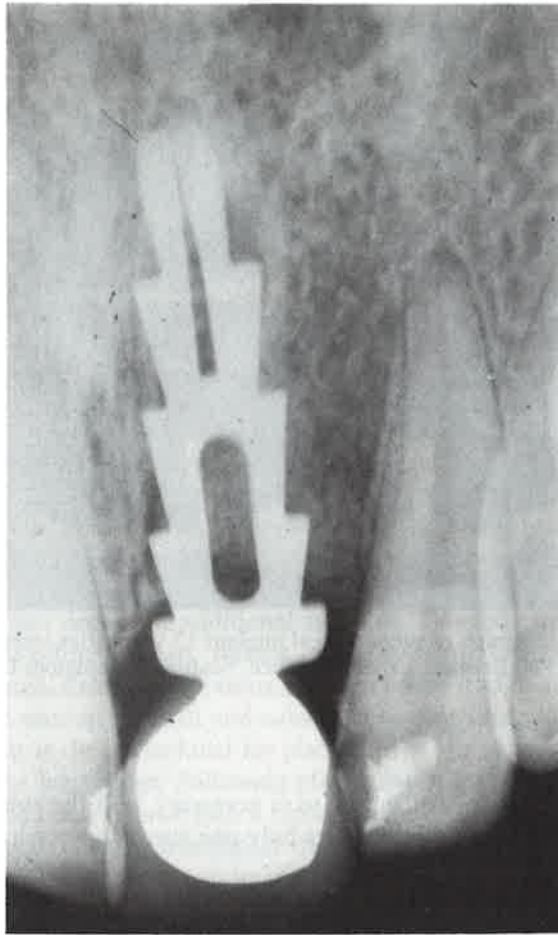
Radiograph of an intermediate blade implant 5 years after insertion. Courtesy of Prof. J. A. Hobkirk, Department of Prosthetics, Eastman Dental Institute, London.
